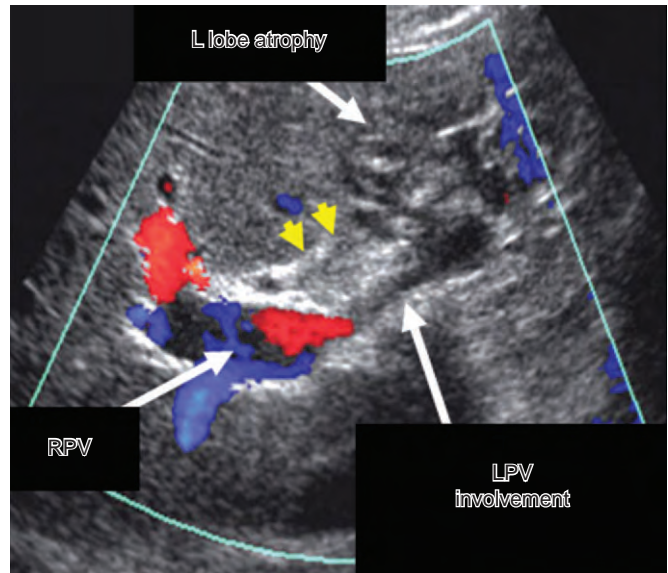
Ultrasound duplex image of hilar cholangiocarcinoma with lobar atrophy (*upper white arrow*). The *lower white arrows* indicate left portal vein (LPV) and right portal vein (RPV) involvement; the *yellow arrowheads* indicate the tumor.
